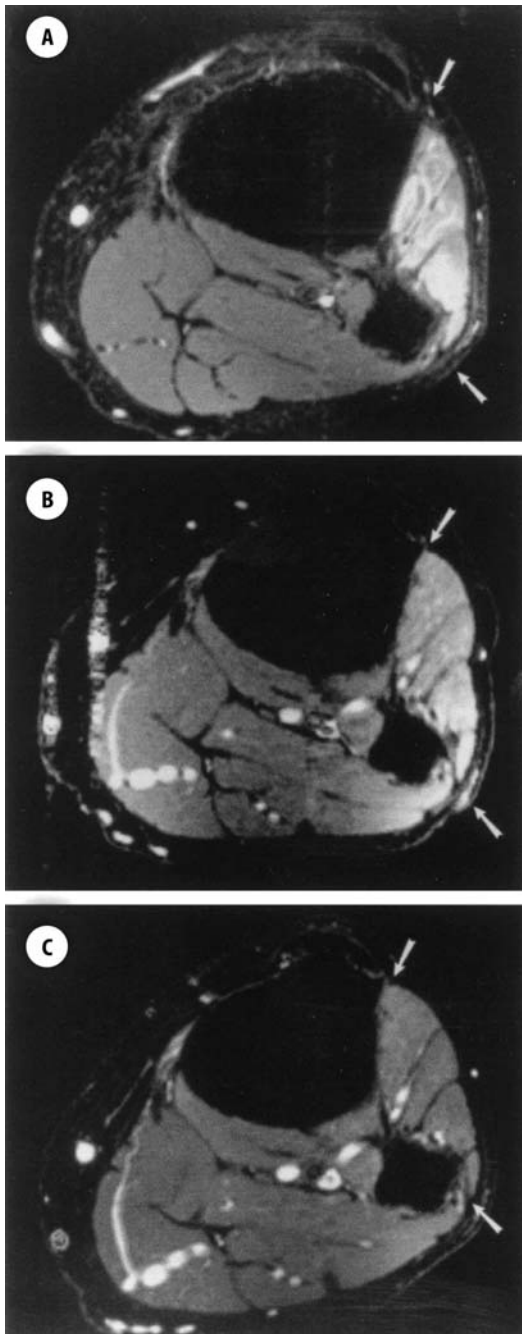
Axial STIR MR images through the lower leg of a 40-year-old male patient who spontaneously developed a severe peroneal nerve palsy. a STIR image of the right lower leg 2 weeks after the onset of symptoms shows bright signal in peroneal-supplied muscles (between white arrows). Motor strength in these muscles was MRC Grade 2. No denervation changes on EMG were present at this time. b At 8 weeks after the onset of symptoms, the STIR signal in the peroneal supplied muscles remained increased but less so than in a. Motor strength had improved to Grade 4 in the involved muscles. Denervation potentials were now present on EMG at this time. c At 20 weeks after the onset of symptoms, the STIR signal was normal in all muscles. Strength and EMG studies were normal as well [23].
